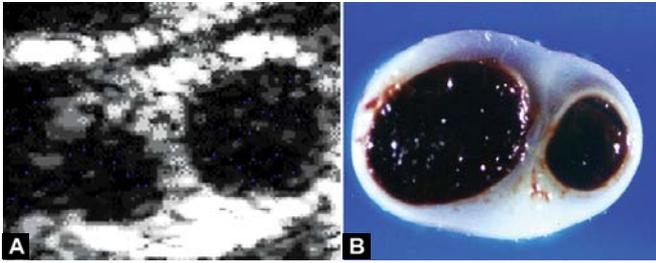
Doppler ultrasound demonstration of Hyrtl anastomosis
